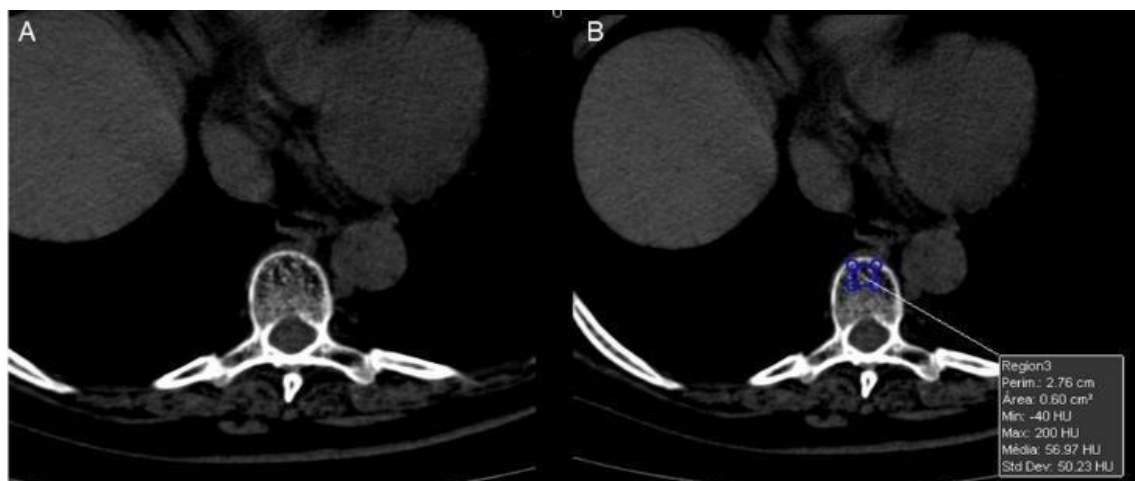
75-year-old woman with osteoporosis. A, Bone density was evaluated in the T12 region. B, A region of interest (area, 1.5–3 cm²) was placed while avoiding cortical bone for the determination of bone density in Hounsfield units. CT, computed tomography.
